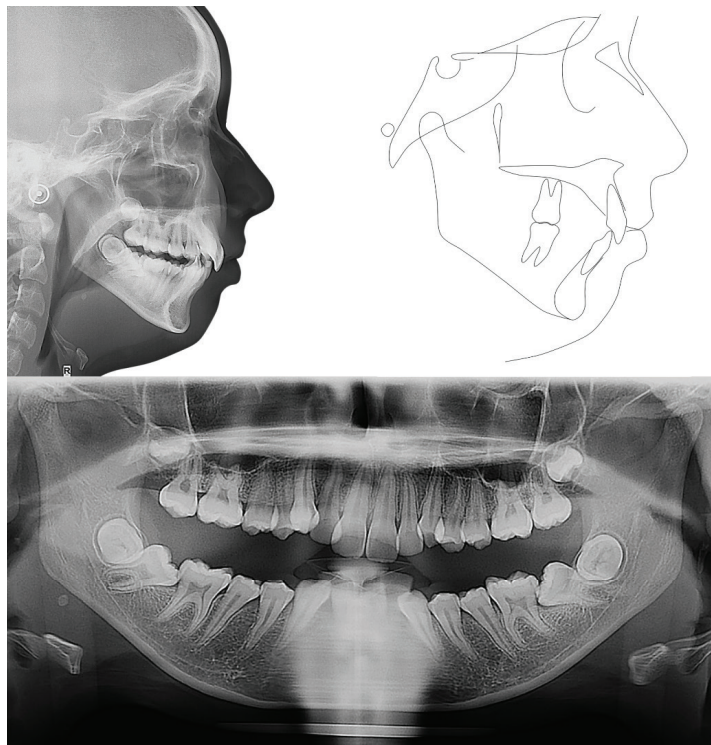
Pre-treatment lateral cephalogram and dental panoramic radiograph of the patient.
